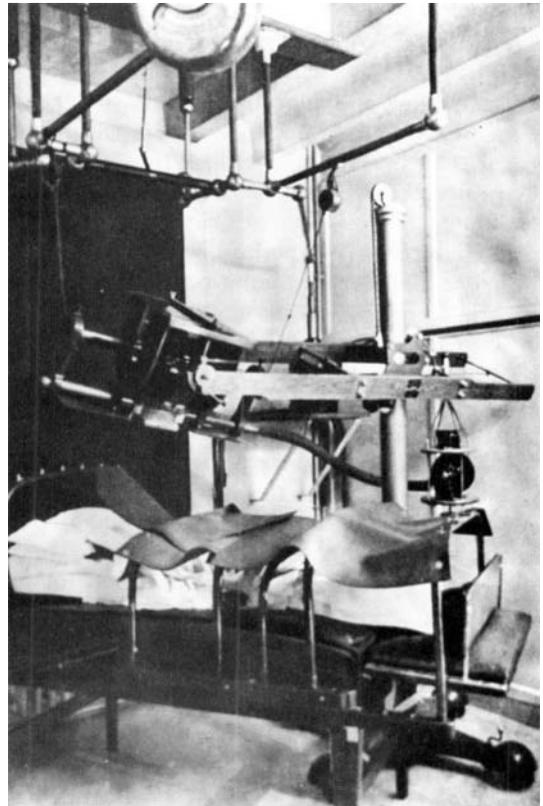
X-ray therapy room (1921).
